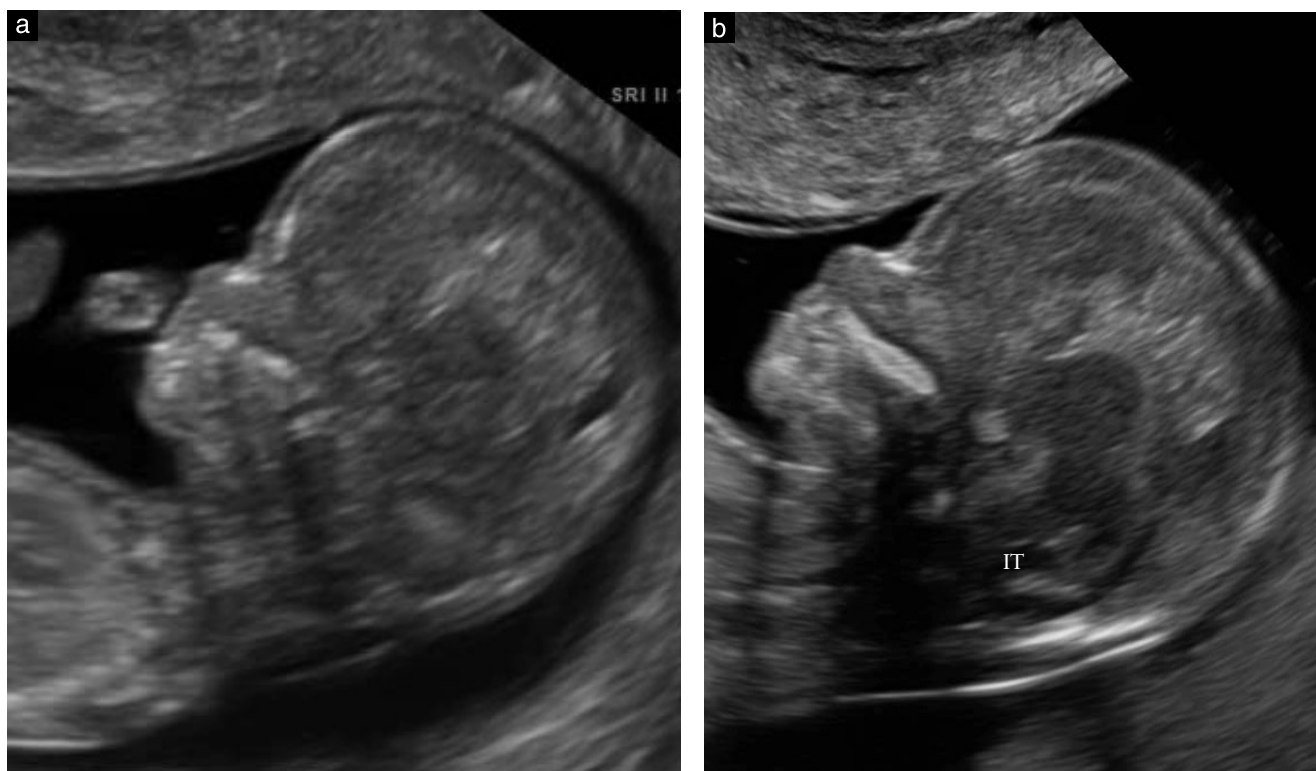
Transvaginal sonography (mid-sagittal plane) in two fetuses at 12 weeks. Although in both cases the resolution was high, in (a) the fourth ventricle and other structures of the brain are not visualized clearly and, although in (b) the intracranial translucency (IT) is clearly visible, the contrast discrimination is poorer than that of mid-sagittal planes of the face obtained transabdominally (cf. Figures 1–3).
